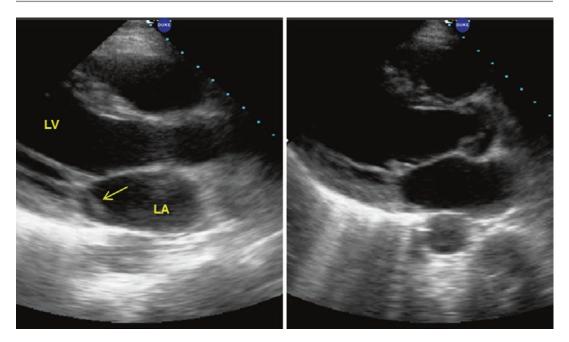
Vegetations can change. These parasternal long axes were taken from a patient with *S. aureus* bacteremia. The left panel shows an elongated vegetative mass
